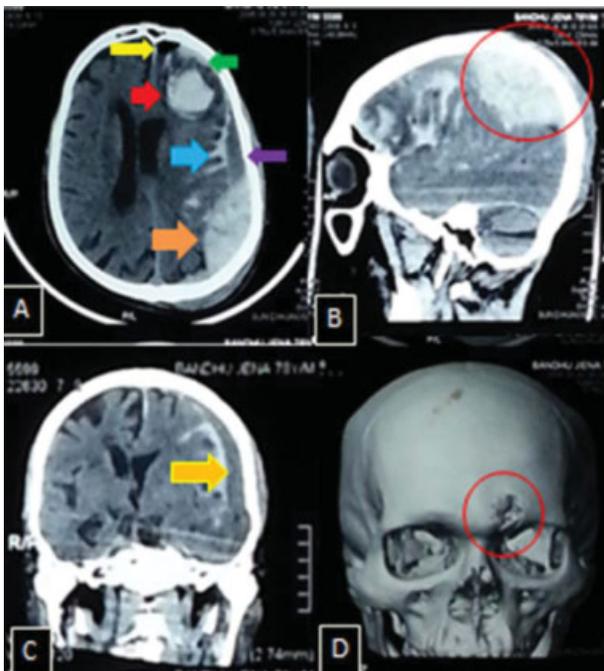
(A) Preoperative NCCT scan axial view showing multiple lesions as follows: orange arrow-EDH, blue arrow-SAH, purple arrow-CSDH, red arrow-ICH, green arrow-ASDH, yellow arrow-pneumocephalus.(B) NCCT sagittal view showing posterior parietal EDH. (C) NCCT coronal view indicating left temporoparietal CSDH. (D) 3D area reconstruction of skull bone showing left frontal depressed fracture. 3D, three-dimensional; ASDH, acute subdural hematoma; CSDH, chronic subdural hematoma; EDH, epidural hematoma; ICH, intracerebral hematoma; NCCT, noncontrast computed tomography; SAH, subarachnoid hemorrhage.
